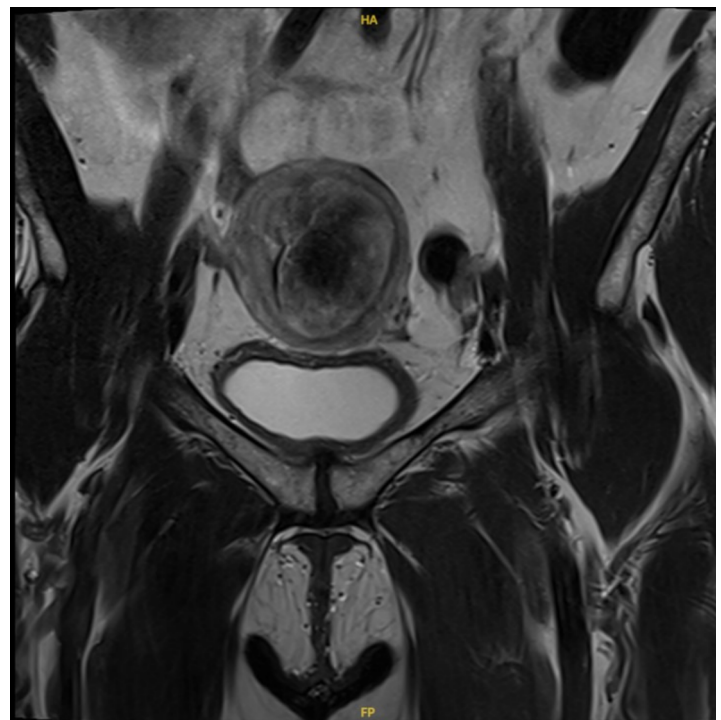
Cross-sectional T1 weighted MRI of patient's pelvis showing a 6.0 x 4.9 x 4.3 cm heterogeneously enhancing pedunculated intracavitary mass, in keeping with a pedunculated intracavitary fibroid. The fibroid shows areas of devascularisation/infarction with early sloughing into the endometrial cavity.
